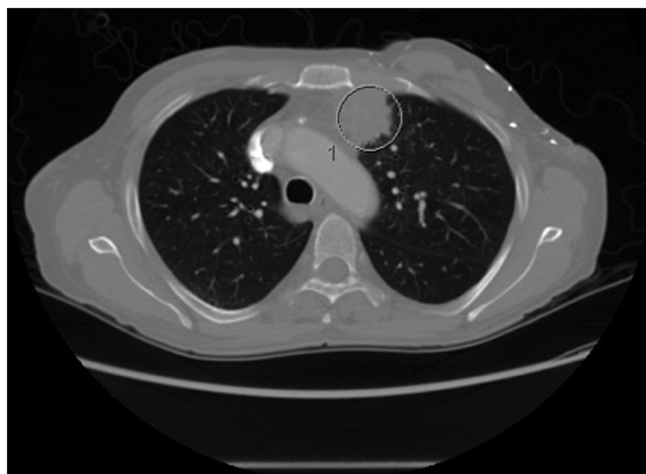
CT of the chest, lung window, demonstrating a mediastinal process invading into the left lung versus a primary pulmonary process invading into the mediastinal border; the appearance was concerning a neoplasm. Further images demonstrate erosion anteriorly into the posterior sternum
